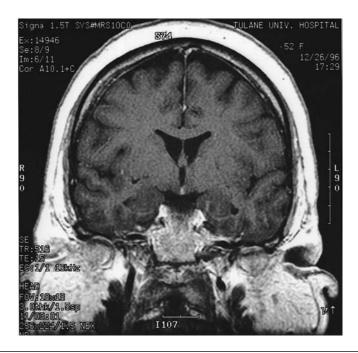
Pituitary suprasellar tumor. Coronal MRI shows intrasuprasellar extension of pituitary tumor.
